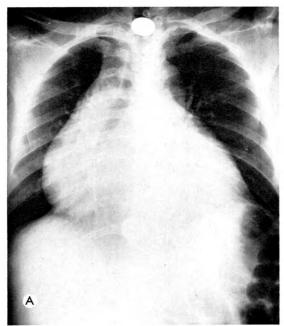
(A) Six foot, anteroposterior, recumbent, midrespiration roentgenogram of the chest of a 43 year old male alcoholic with suspected pericardial effusion. Old pleural disease is seen at the right base. Pericardial effusion was not demonstrated by any tests and the patient was presumed to have cardiac enlargement due to nutritional heart disease. (B) Photoscan of cardiac blood pool made with tracer dose of 700 μc I<sup>131</sup> iodipamide sodium. Note reorientation marker for xyphoid process, and note also lesser blood pool in liver.
